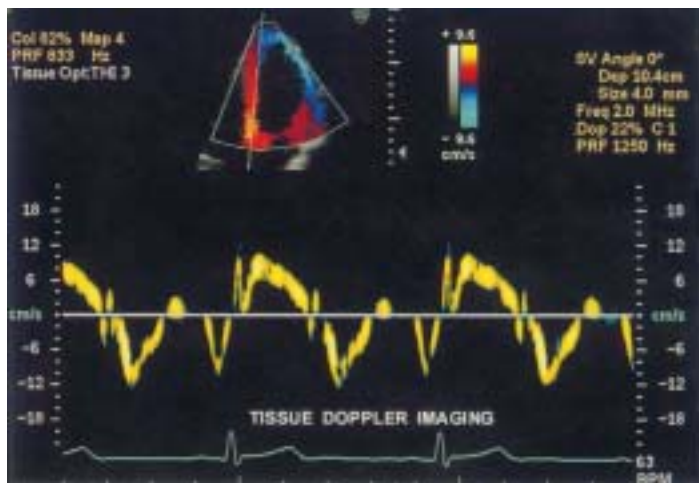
Tissue velocity spectral Doppler. A new method for assessment of segmental LV function. Encoding LV wall Doppler shift permits both enhanced imaging of regional wall motion with color flow display of LV wall Doppler velocities as well as quantification of segmental motion by spectral Doppler. (Image courtesy of ATL Ultrasound, Bothell, WA.)
